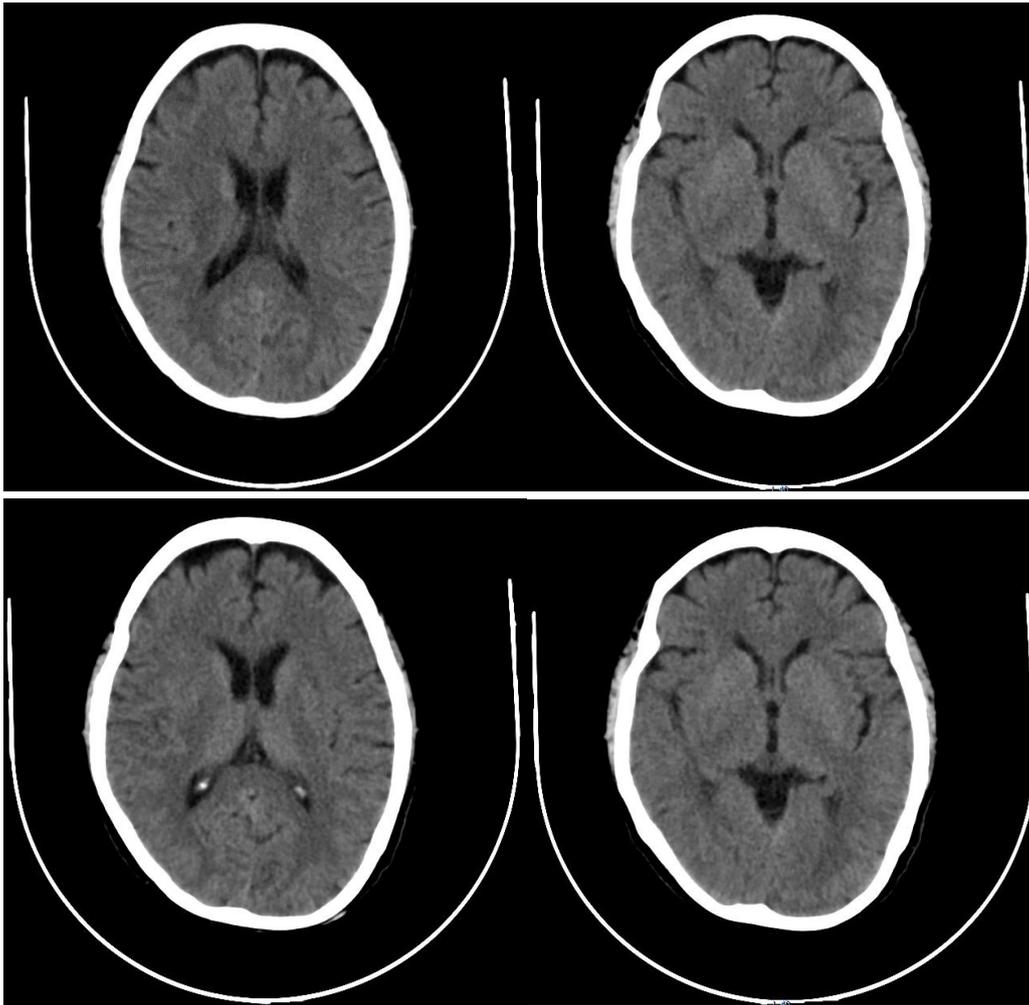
Non-contrast CT scan of the head shows a subacute ischemic cerebral infarction in the right internal capsule.
